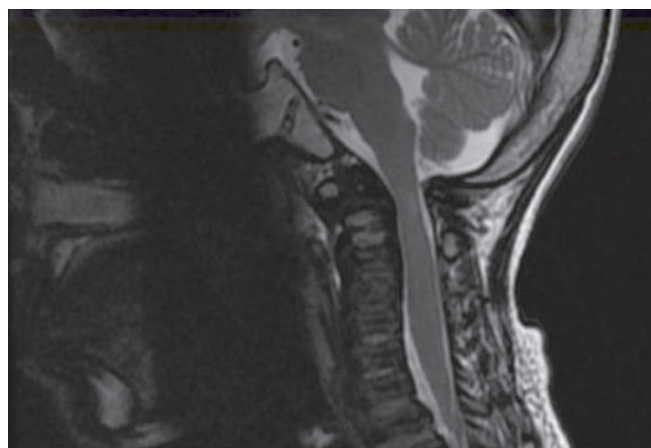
MRI of cervical spine (T2-weighted image) documenting obscure tip of dens with soft tissue/pannus around it. Atlas is dislocated anteriorly with consequent compression of the spinal cord at the C1 vertebral level and cord oedema.
